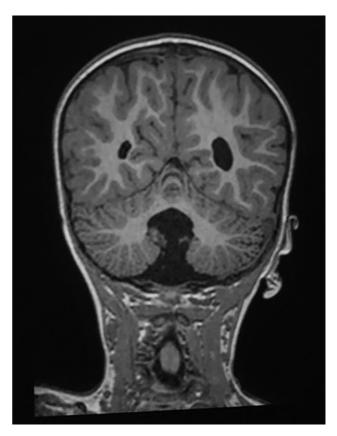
Magnetic resonance imaging of the skull showing dilatation of the fourth ventricle.
